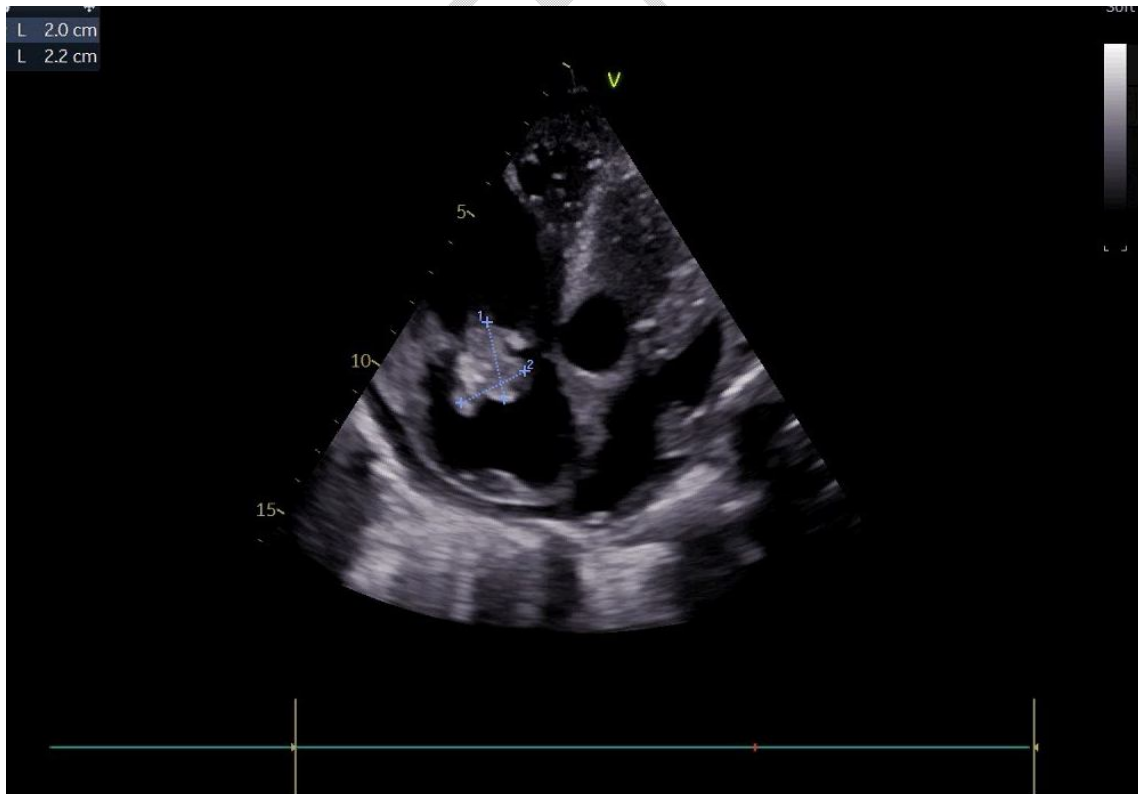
Trans-aortic ultrasound showing vegetation on the tricuspid valve measuring 22x20mm
